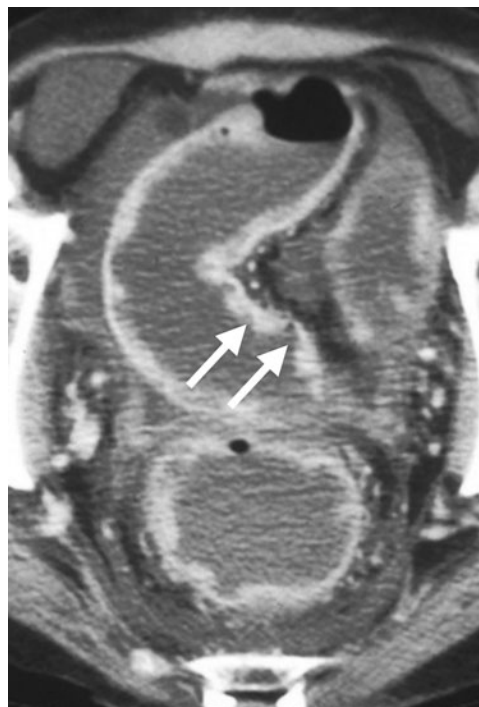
Ulcerative colitis. Axial computed tomography (CT) demonstrates deep ulcerations (arrows), with intervening surviving mucosa producing inflammatory pseudopolyps in this patient with severe disease. Notice the ascites
